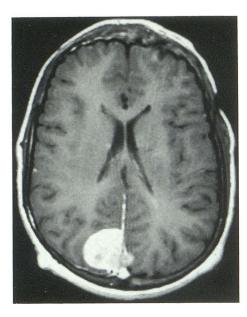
Transitional meningioma; 16-year-old boy with Type 2 neurofibromatosis. Contrast-enhanced axial T1-weighted (600/20, TR, TE) MR shows bilobed, enhancing dural-based mass extending on both sides of the superior sagittal sinus posteriorly.
